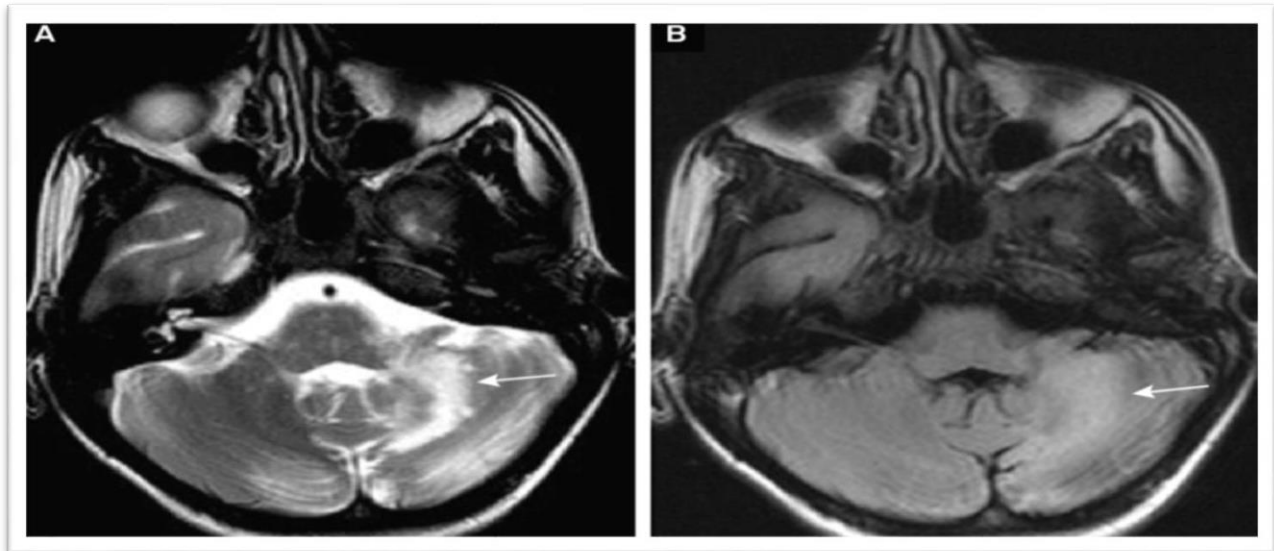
(A) Axial T2-weighted and (B) axial FLAIR-weighted brain MRI shows asymmetric hyper intense signal in the cerebellum evolving to the left cerebellar hemisphere and middle cerebellar peduncle.
